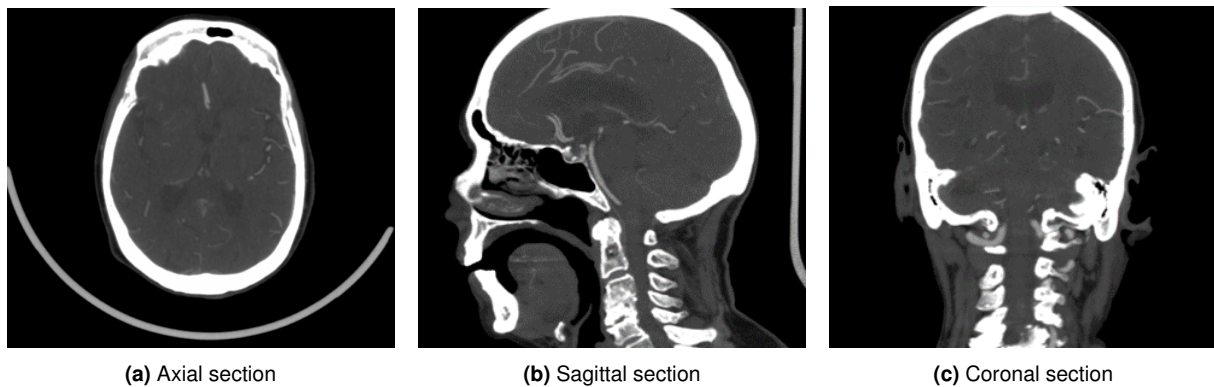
Representation of the 3 sections obtained by reformatting the CT scan. Source: Images taken and adapted from HSM database.
